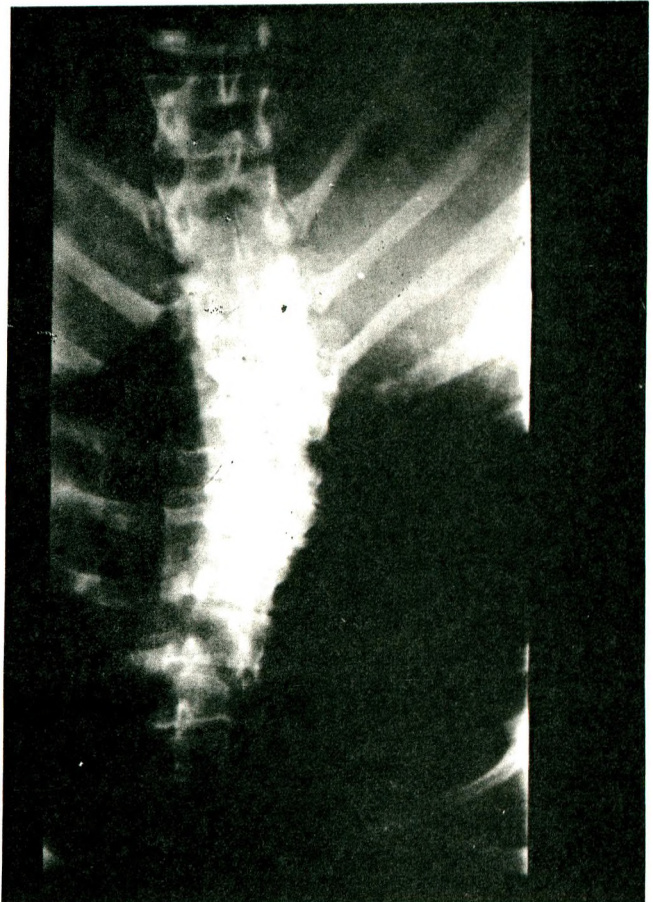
X-ray of the vertebral column (scoliosis and spina bifida)
